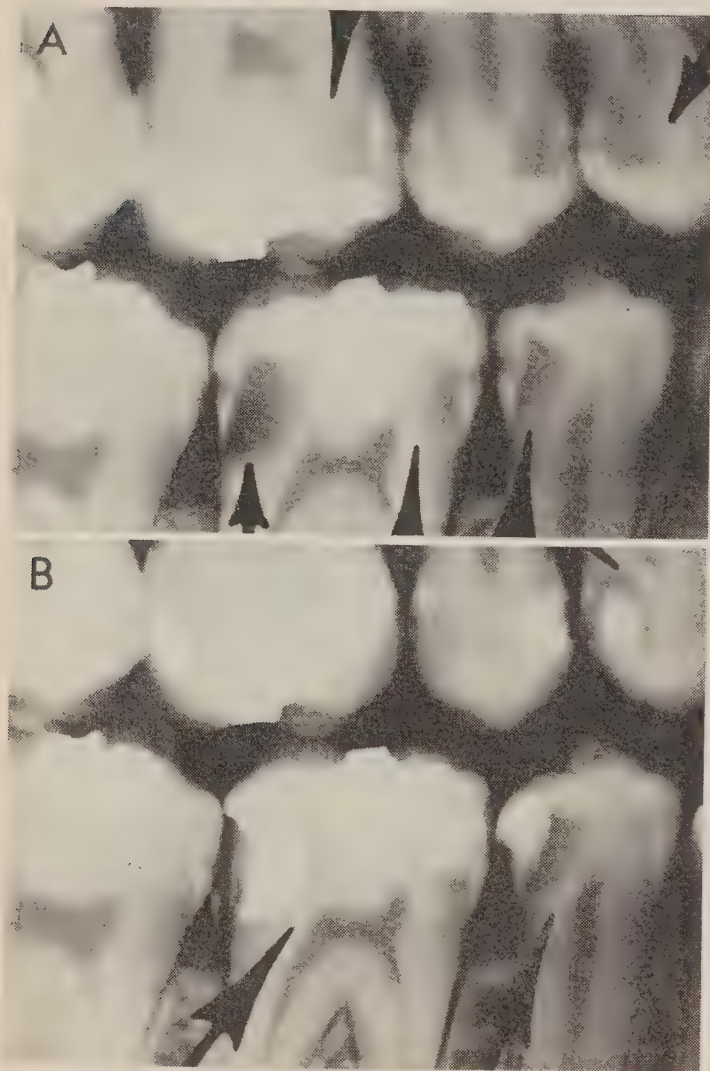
A, radiograph showing deep carious lesions in the right posterior teeth of a 16 year old patient. B, the same teeth 12 weeks after indirect pulp capping. Arrows indicate radiopaque areas of apparently remineralized dentine.
